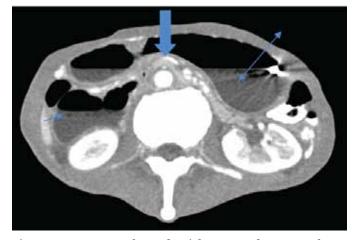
Contrast enhanced axial computed tomography at level of D<sub>3</sub>. Stomach is distended with nasogastric tube in situ (double headed arrow), D2 and proximal D3 are dilated (short arrow) and the mid D<sub>3</sub> is collapsed ventral to the aorta (open arrow). Note also the cachectic body habitus.
